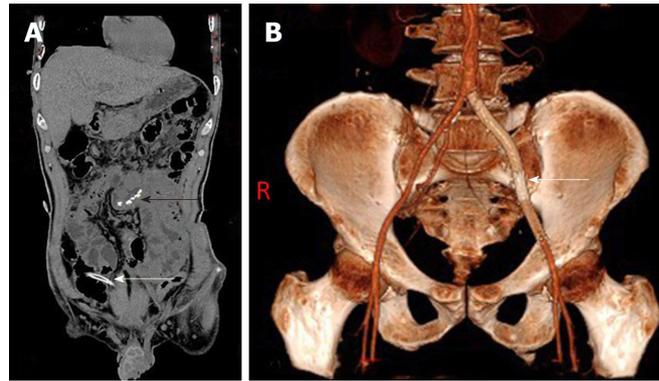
Abdominal computed tomography findings after partial small intestine resection and stent implantation. A: The nail of the linear cutting closer is shown (black arrow) along with the abdominal cavity silicone drainage tube (white arrow); B: Three-dimensional computed tomography angiogram reconstruction confirmed good position of the left common iliac artery stent (white arrow).
